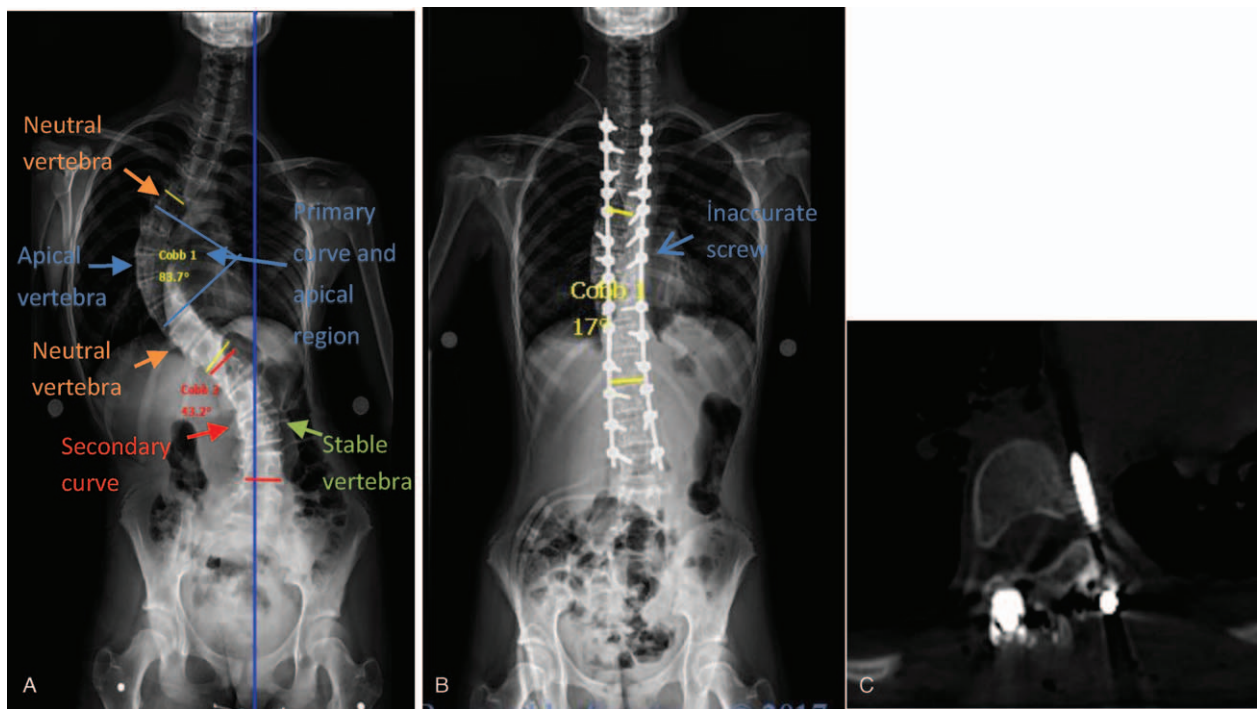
(A) A 13-year-old girl with idiopathic scoliosis Lenke type 1. (B) The postoperative Cobb angle is 17°. (C) The postoperative CT shows that T8 screw was abutting the aorta and this screw was removed with a second operation. CT=computed tomography.
